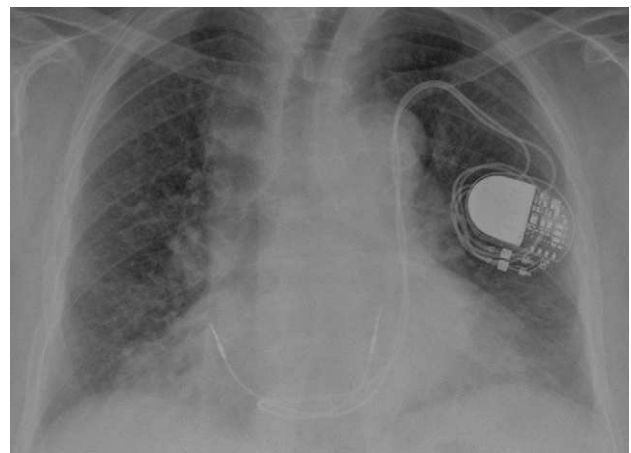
Posteroanterior chest radiograph, with leads inserted through the left superior vena cava. Distal ventricular electrode anchored in the right ventricular outflow tract.
